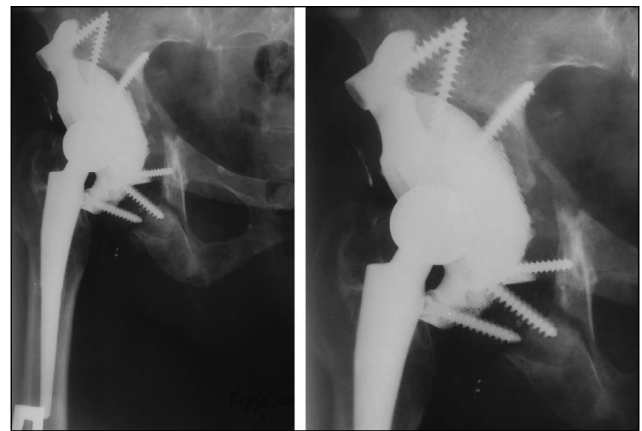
Postoperative control X-ray after 3 months.
